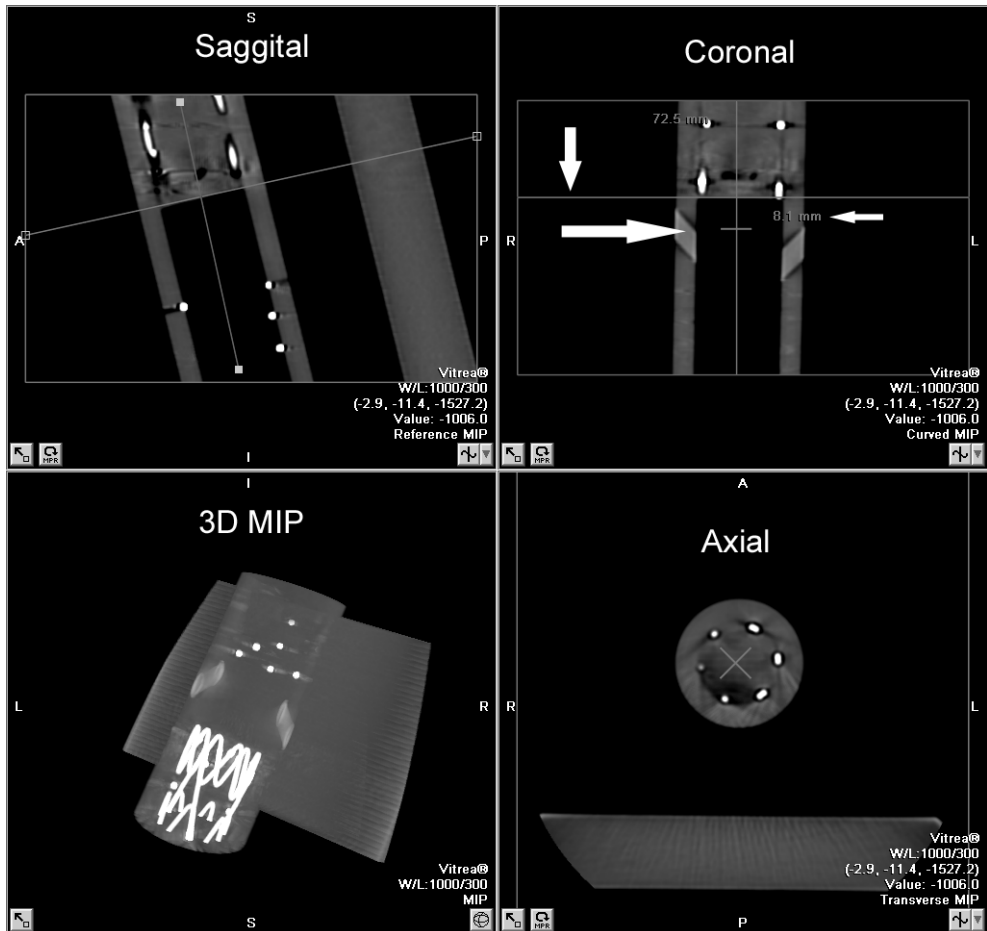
CT image reconstruction with Vitrea2 software. The caudal margin of the renal artery is identified (coronal image, largest arrow) on the axial image and the “ruler” is set to 0 mm. Afterward, the axial image is used to determine the first image with a circumferential view of the stent (axial image and coronal image, vertical arrow). The measurement is now taken (coronal image, smallest arrow).
